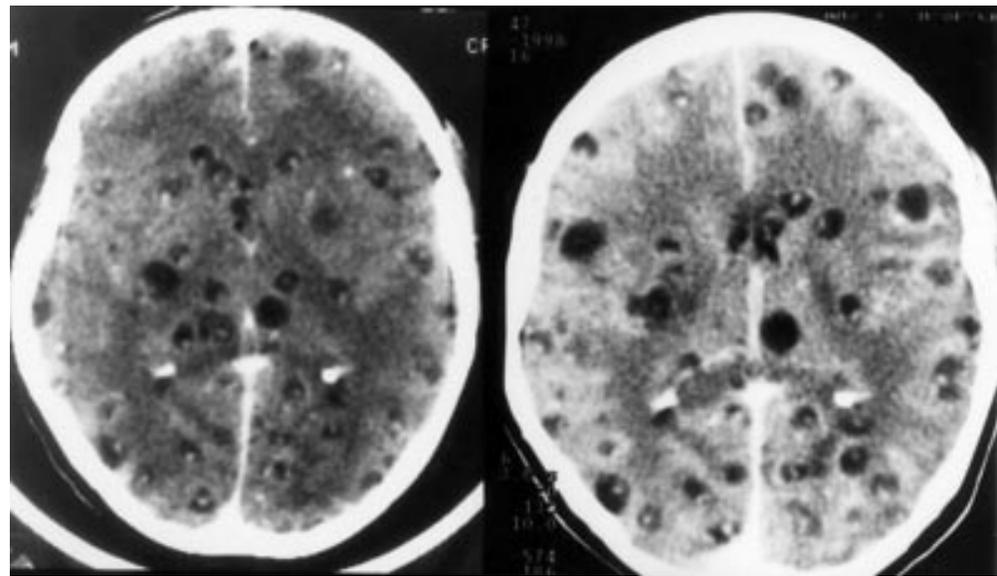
Postcontrast CT of a patient with seizures and intracranial hypertension syndrome, who received albendazole treatment. Left: multiple active cysts with the scolex in their interior (vesicular phase) and calcifications. Right: 16 months after treatment more cysts appeared, and some of them increased in size.
